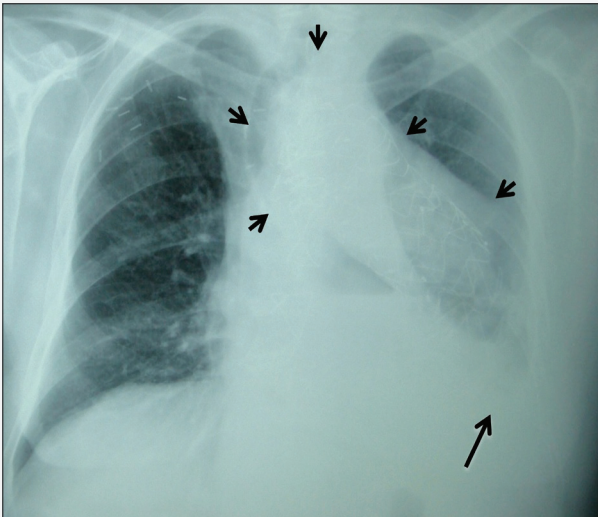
The posterior-anterior (PA) chest X-ray showing the blunt image of the left pleura (large black arrow) and aneurysmatic thoracic aorta with stent that enlarges the mediastinum, displaces the trachea to the right and superimposed on the left lung (short black arrows).
